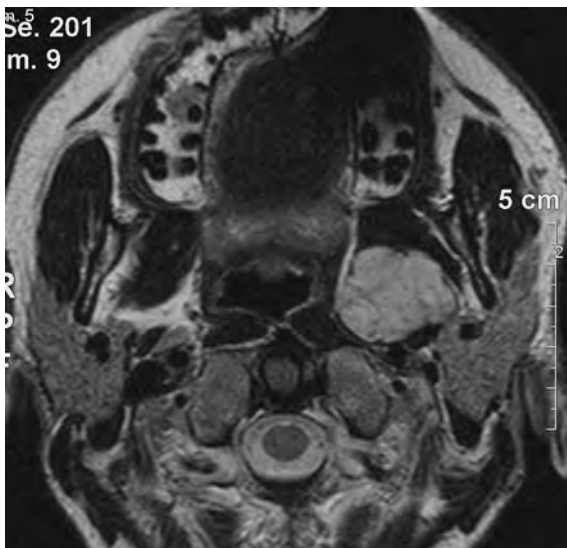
Pleomorphic adenoma extending to the left anterior parapharyngeal space with typical high signal on T2-weighted images
